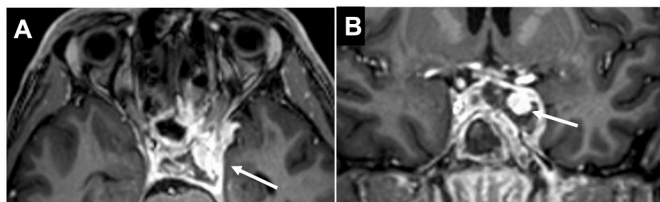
A-B Axial and coronal magnetic resonance images (T1-weighted) demonstrating sacular enlargement of the left intracavernous carotid artery (arrows in A-B).
